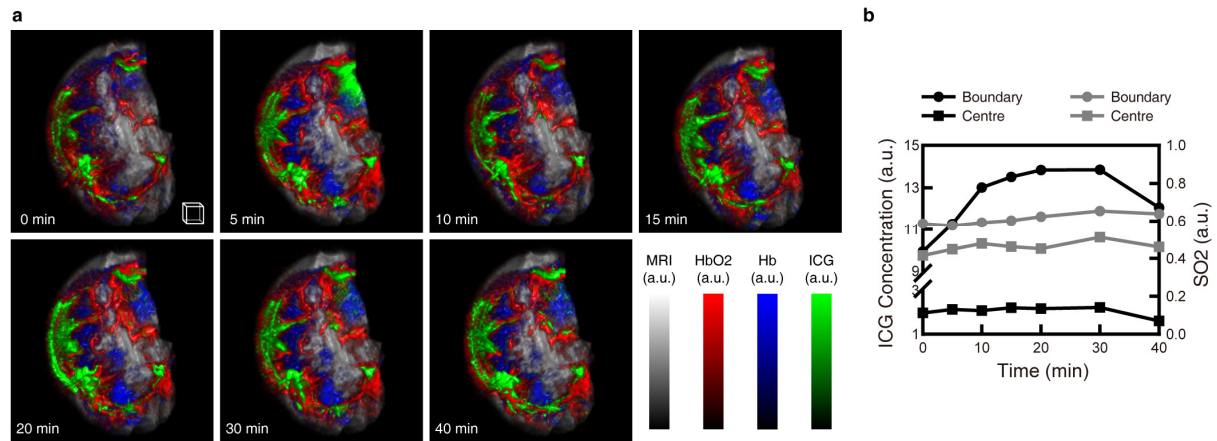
Temporal anatomical-molecular imaging of ICG perfusion inside 4T1 tumor. a 3D fusion display of the Hb, HbO₂, ICG distributions on top of a co-registered MRI image of the 4T1 tumor microenvironment. PAT images were acquired at a 5 minute interval. b Time trace of the ICG concentration and SO₂ of the hypoxic centre and boundary region of the tumor. Scale box, 1 mm³. See Supplementary Video 3.
